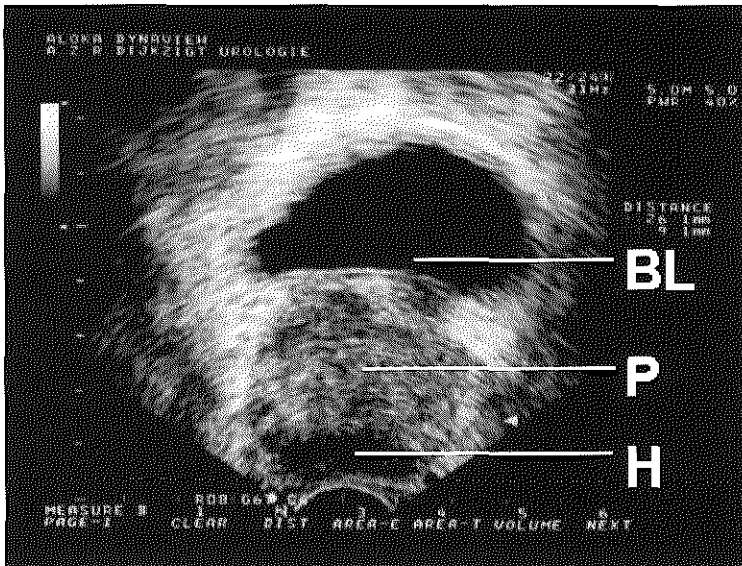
Transrectal ultrasonography (TRUS) showing a transverse section of the prostate. A part of the bladder is also visible. In this case a prostatic adenocarcinoma is visible as a hypoechoic lesion (dark) at the bottom. (Abbreviations :BL: bladder; P: prostate; H: hypoechoic lesion)
